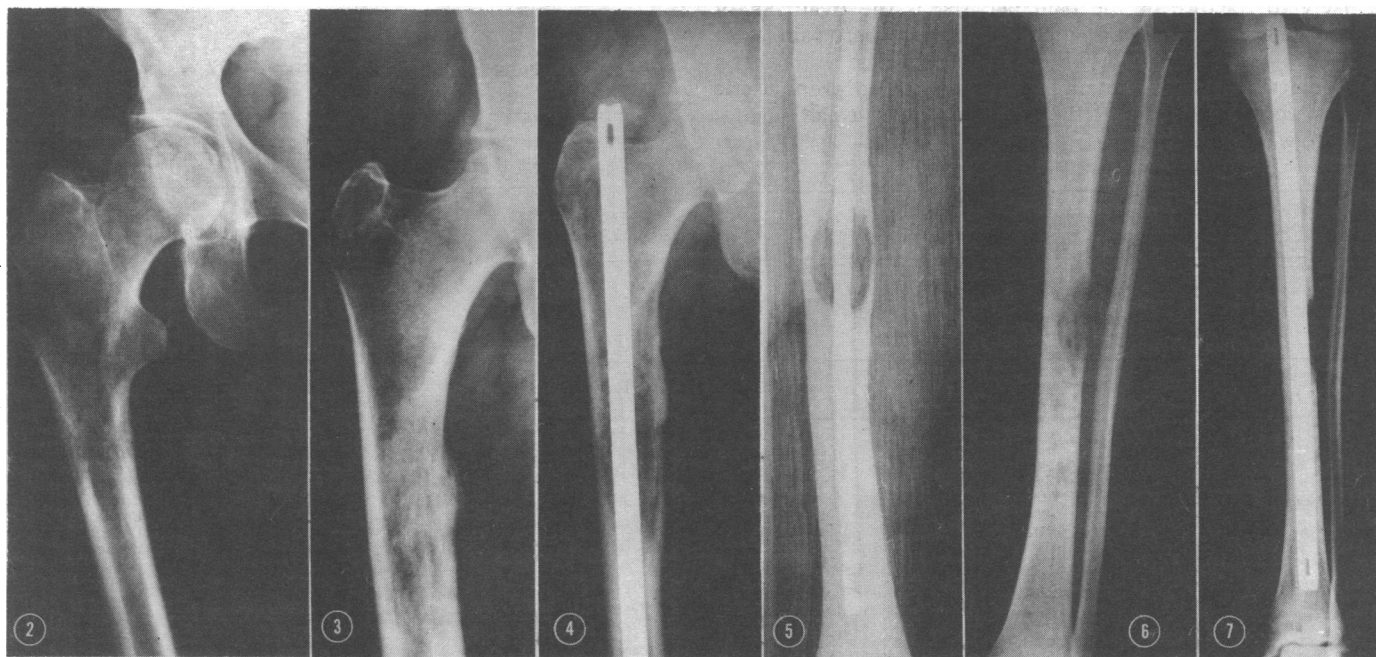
Radiograph showing over 75% cortical involvement. FIG. 3—Case 27. Radiograph showing 50% cortical involvement of the shaft of the femur. FIG. 4—Case 27. Radiograph showing prophylactic internal fixation with a Küntscher nail. FIG. 5—Case 22. Radiograph showing prophylactic internal fixation of the humerus with a Küntscher nail. FIG. 6—Case 23. Radiograph showing the osteolytic lesion involving 50% of the shaft of the tibia. FIG. 7—Case 23. Radiograph showing prophylactic internal fixation of the tibia with a Küntscher nail.
